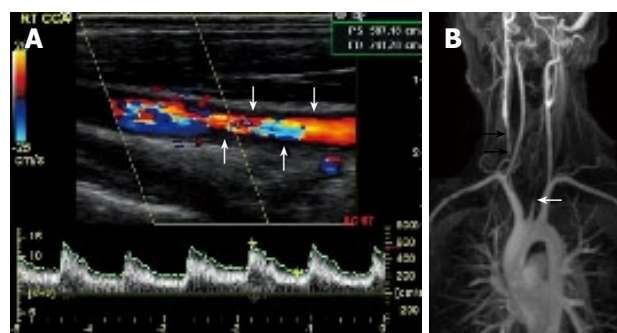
Ultrasound image of the right common carotid artery showing wall thickening (arrows) and blood flow with a significantly enhanced peak systolic velocity (PS > 587 cm/s), indicating a severe stenosis (A) and magnetic resonance angiography showing occlusion of the left common carotid (white arrows) and stenosis of the right common carotid (black arrows) arteries (B).
